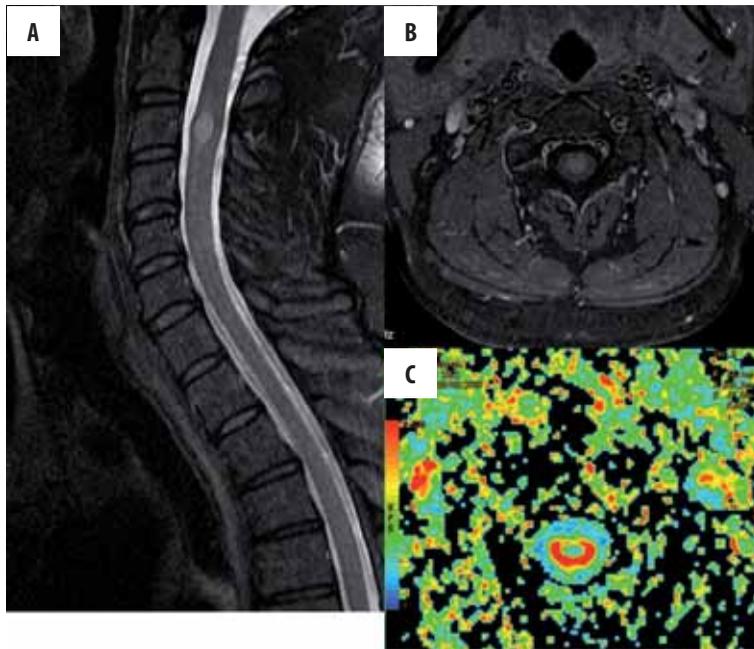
Small intramedullary tumor. MRI: sagittal T2-weighted (A), axial T1-weighted fat-suppression (B) and diffusion tensor axial (C) images. Plain sequences clearly show the tumor, while DTI provides visualization of the displacement of the spinal cord's white matter tracts.
